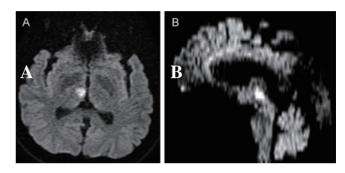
(A) Axial diffusion-weighted MRI showed an acute ischemic infarct in the right medial thalamus. (B) Mid-sagittal diffusion-weighted MRI showed right medial thalamic infarct without midbrain involvement.
